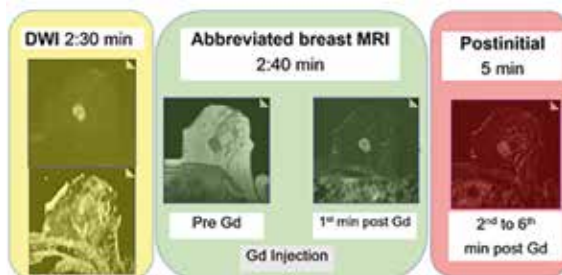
Three sections of the MRI protocol. The centerpiece was the abbreviated breast MRI (ABM), consisting of the pre- and the first scan post Gadolinium (Gd) injection. Considering an average injection time of 10 seconds and a subsequent delay of 30 seconds, this gave an average acquisition time of 2:40 minutes. The ABM was expanded by five additional post-contrast scans (+5 minutes: Postinital) and by a fast DWI sequence (+2:30 minutes).
